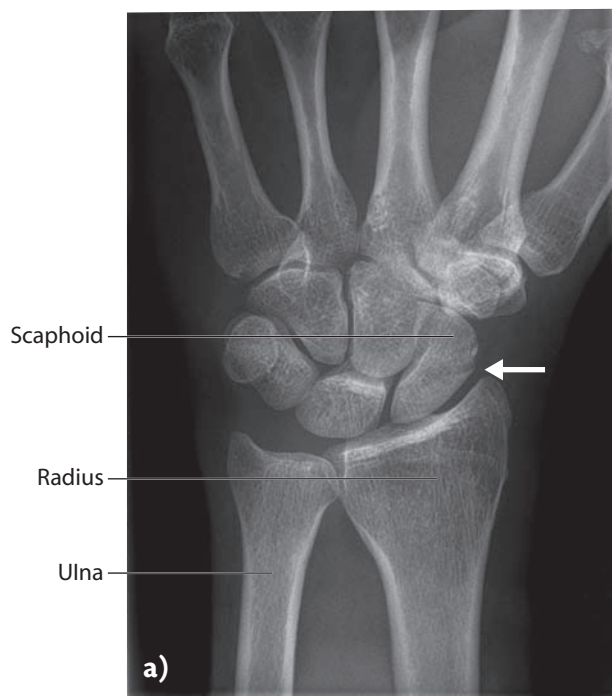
Radiology and imaging will secure the diagnosis of scaphoid fracture. a) X-ray of the wrist showing a scaphoid fracture (arrow); b) CT scan will show a scaphoid fracture (see arrow).
